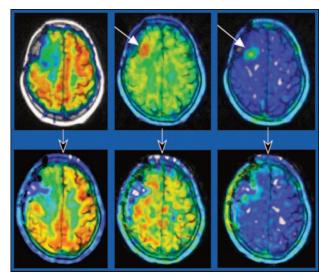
Image results differ with varying radiotracers (left, ¹⁸F-FDG; middle, ¹¹C-methionine; right, ¹¹C-choline) in a patient with brain tumors before (top row) and after (bottom row) radiation therapy. The ¹⁸F-FDG results in a broad accumulation of tracer in normal brain as well as the lesion, whereas the accumulations of methionine and choline are more specific.
